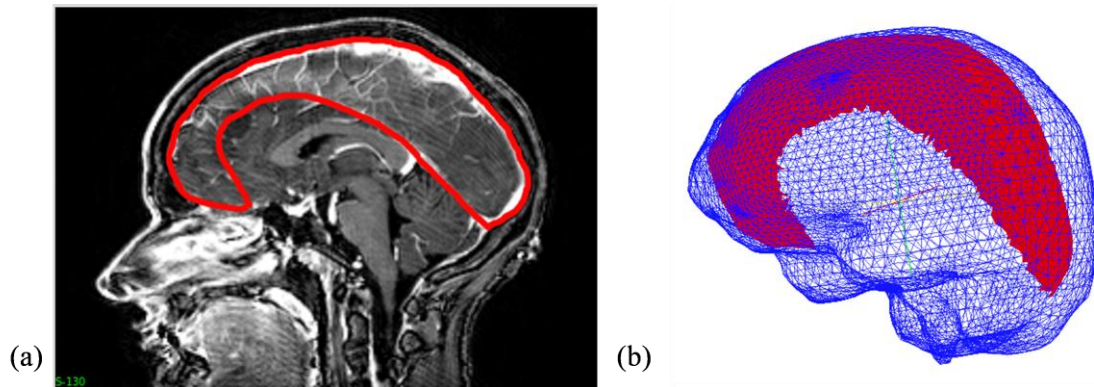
Falx segmentation procedure. (a) Manual periphery drawn around falx on gadolinium enhanced MRI (b) segmented falx overlaid with the mesh.
